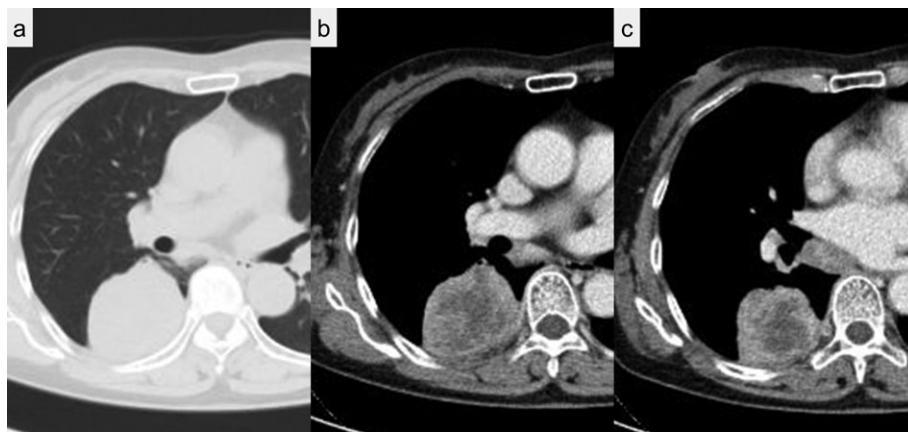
Computed tomography showed a tumor in segment 6 of patient's right lung, which was in wide contact with the parietal pleura in a pulmonary window image (a) and in a mediastinal window image (b). An enlarged subcarinal lymph node suspected of being metastasis was also detected (c).
